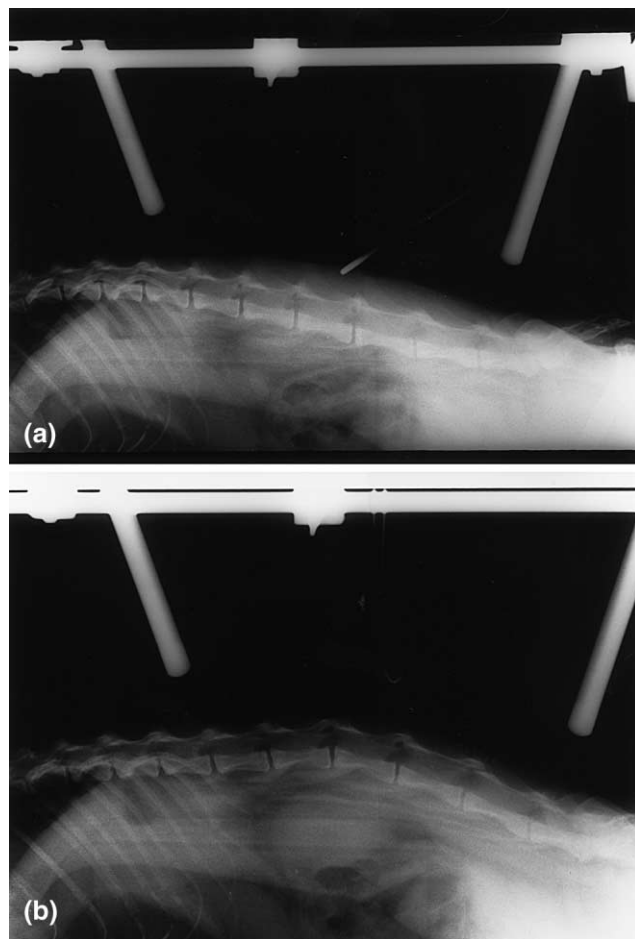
Radiographs of the lumbar spine during rest (a) and during full flexion elicited by the displacement via the L-4/5 supraspinal ligament (b).
